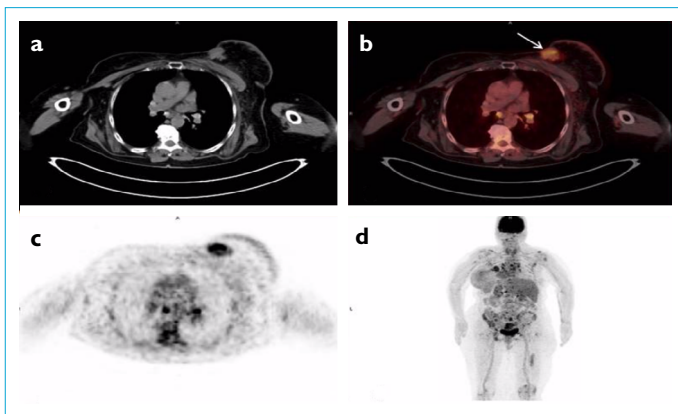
(a-d). Transaxial CT (a), fused (b), PET (c) and MIP (d) images of the 18F-FDG PET/CT scan. Primary tumor in the left breast is shown with arrow in the fused image.
